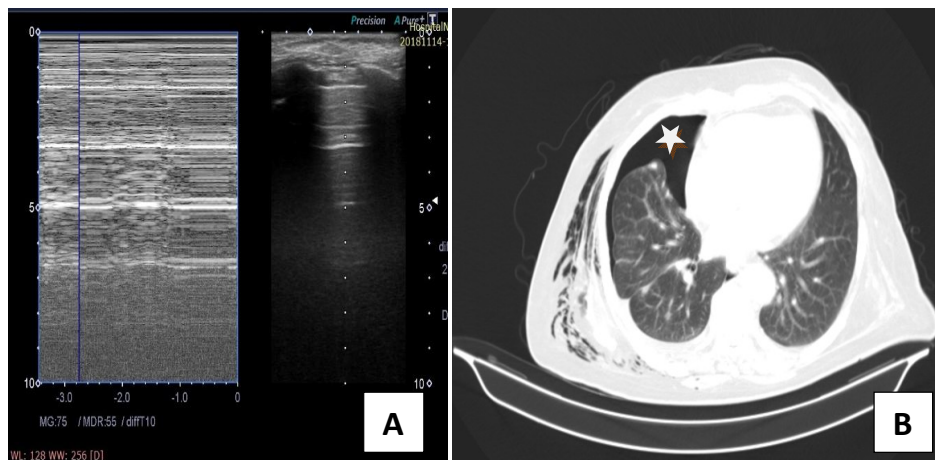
A 70 years old female patient, that was a known case of metastatizing breast cancer, her complain was severe dyspnea and chest pain following chest tube insertion for pleural effusion. (A) Chest US B mode showed absence of lung sliding, M mode showing barcode sign that's specific for pneumothorax, no sliding, and no seashore sign. Fig (B): Post contrast CT, lung window axial view, showed right side mild pneumothorax (Star) with decrease left lung volume. Surgical emphysema is also noted. Diagnosis: Right side pneumothorax and surgical emphysema
